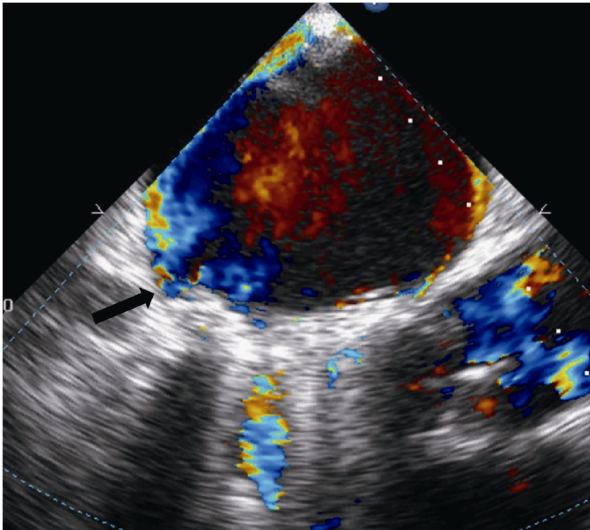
Postoperative transesophageal echocardiography demonstrating small residual leak (black arrow).
